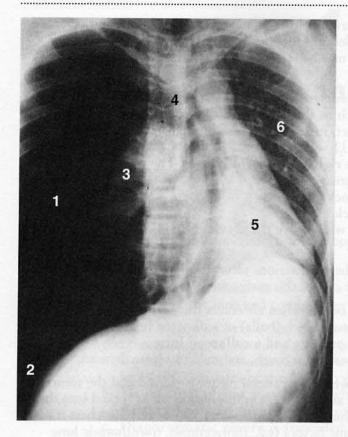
Anteroposterior radiograph showing tension pneumothorax as a result of penetrating chest trauma to the right side. *1* = hyperlucent lung field; *2* = hyperexpansion lowering the right diaphragm; *3* = collapsed right lung; *4* = deviation of the trachea; *5* = mediastinal shift; 6 = compressed left lung. (Adapted with permission from Freundlich IM, Bragg DG: *A Radiologic Approach to Diseases of the Chest*, 2nd ed. Baltimore, Williams & Wilkins, 1997, p 270.)
